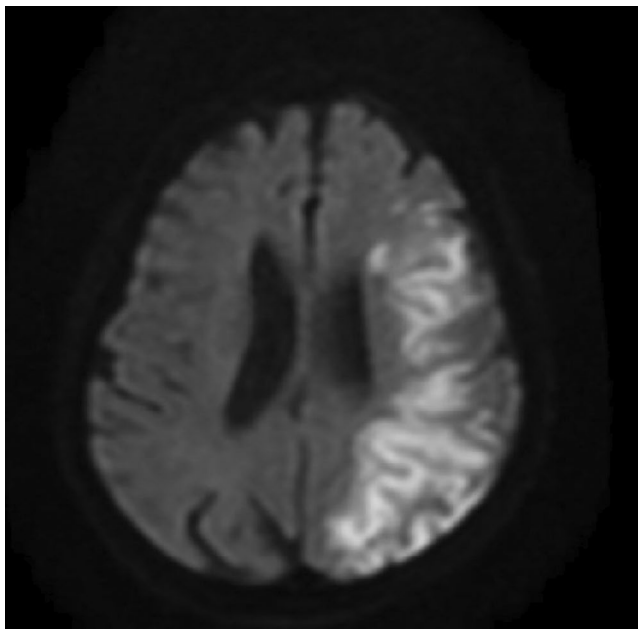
MRI axial DWI image
